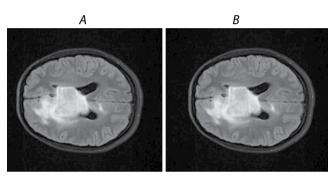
Diffuse glioma (T2-FLAIR, ax). A – raw data; B – ScaleIntensity transformed data.
